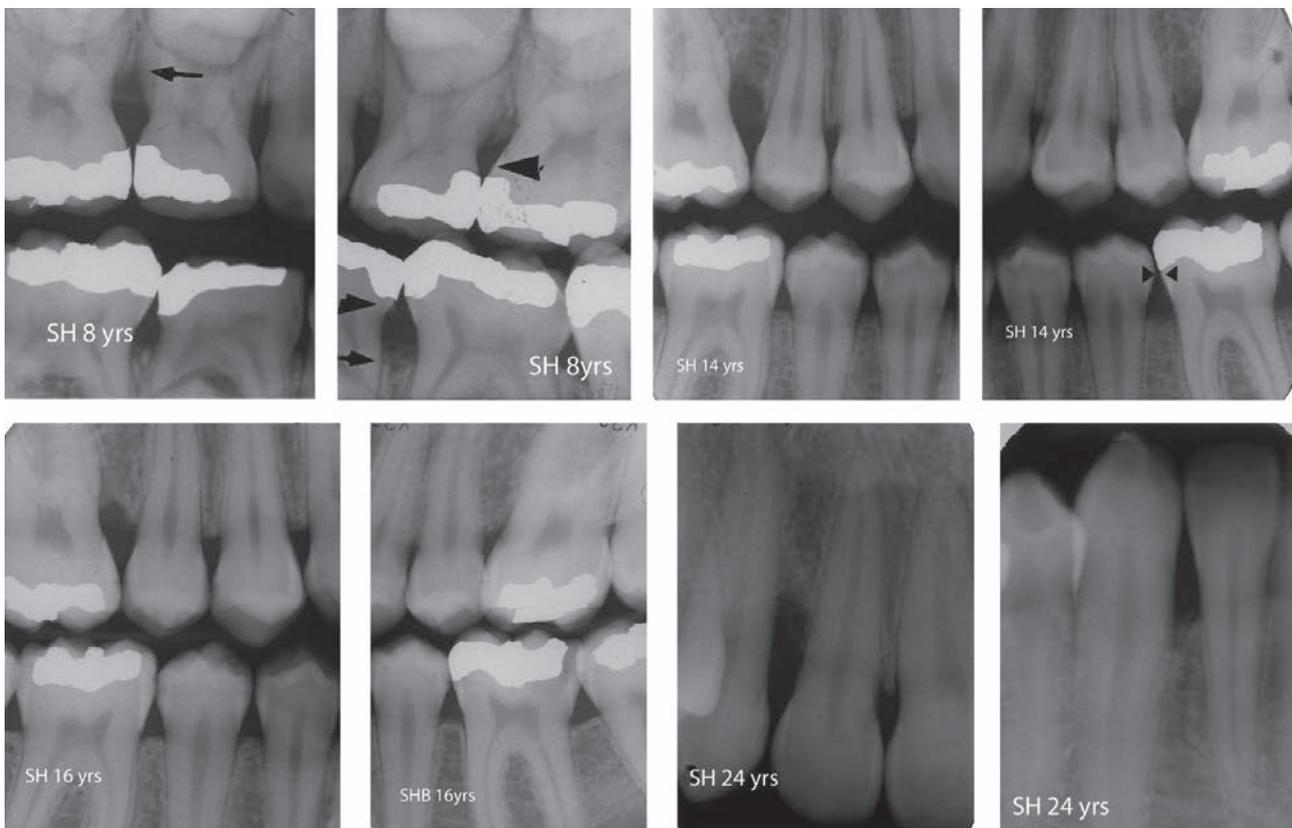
A 14-year-old boy with localized aggressive periodontitis (c, d). Previously obtained and filed radiographs from the age of 8 years show loss of bone support (a, b) (arrows).
